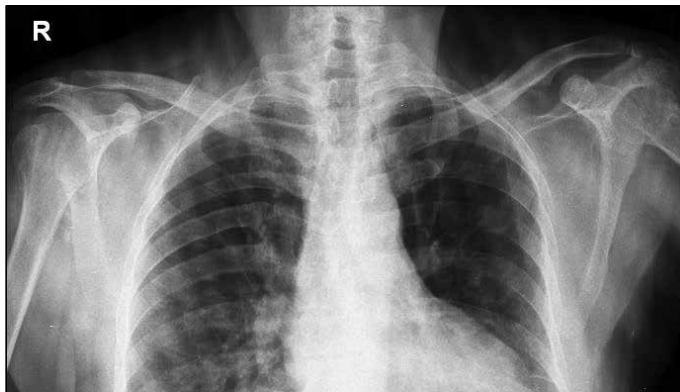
Radiography of both shoulders 4 months after injury
